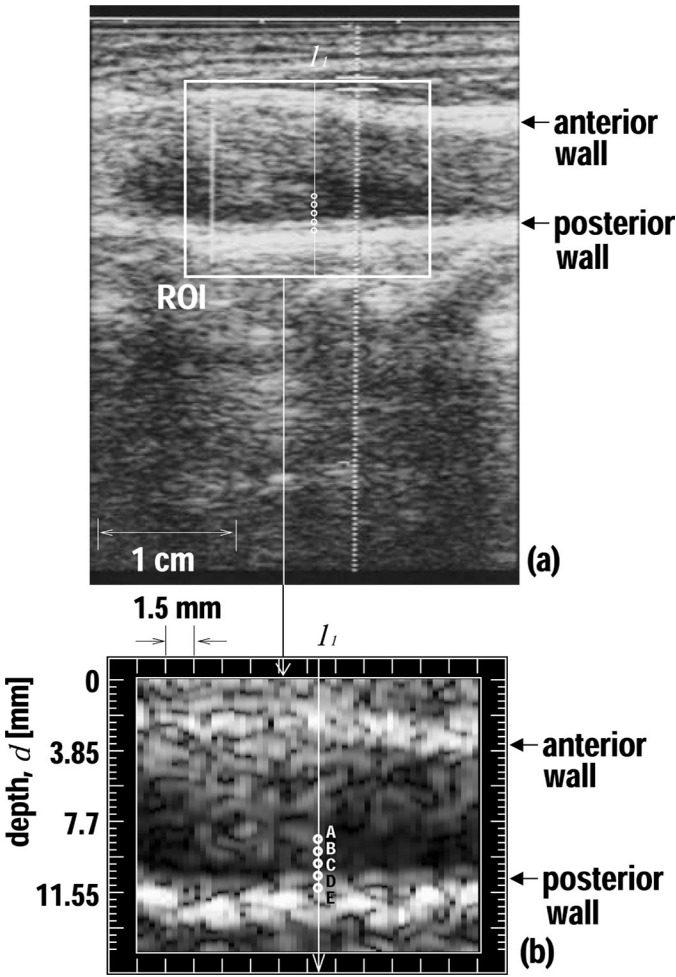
(a) B-mode image of the human carotid artery of a 50-year-old male obtained by standard ultrasonic diagnostic equipment. (b) B-mode image within the ROI, which is reconstructed from the amplitude, $|z(t; d; \ell)|$, of the quadrature demodulated signal. Amplitude, $|z(t; d; \ell)|$, at position ℓ_1 is plotted as a function of depth in Fig. 3, and displacements of points A, B, C, D, and E are shown in Fig. 4(a).
